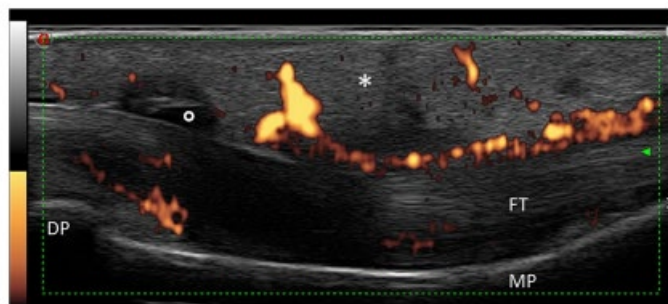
Tenosynovitis of the III right flexor tendon characterized by marked synovial proliferation, a moderate increase of the tendon thickness and a thickened and hypoechoic peritendineal tissue. Synovial sheath widening (circle) associated with soft-tissue edema (asterisk). Power Doppler function revealed diffuse and severe vascular signal inside and around the tendon sheath (Grade 3). DP, distal phalanx; FT, flexor tendon; MP, medial phalanx.
